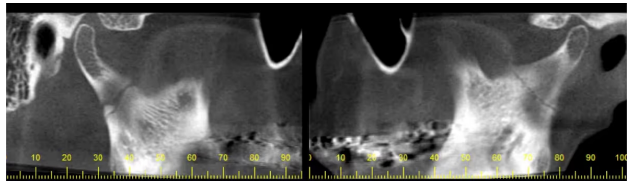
CBCT Imaging Depicting Bilateral Condylar Fractures
